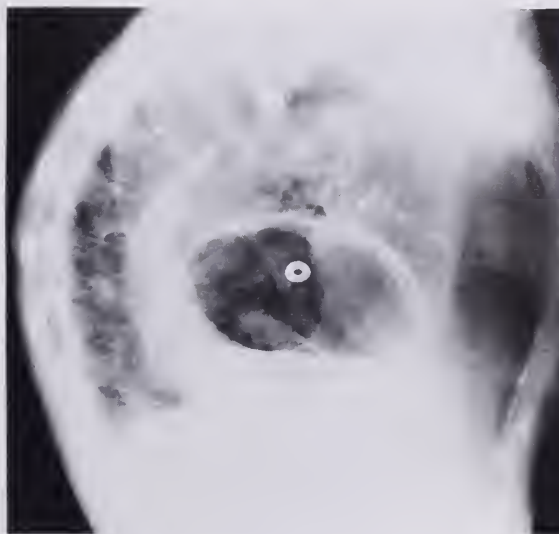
(Case 2).—Lateral view of chest x-rays reveals double air fluid levels within thoracic cavity.
